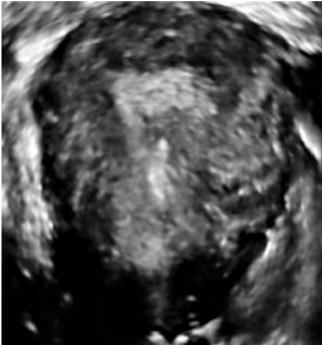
3D-ultrasound of adhesions after curettage
